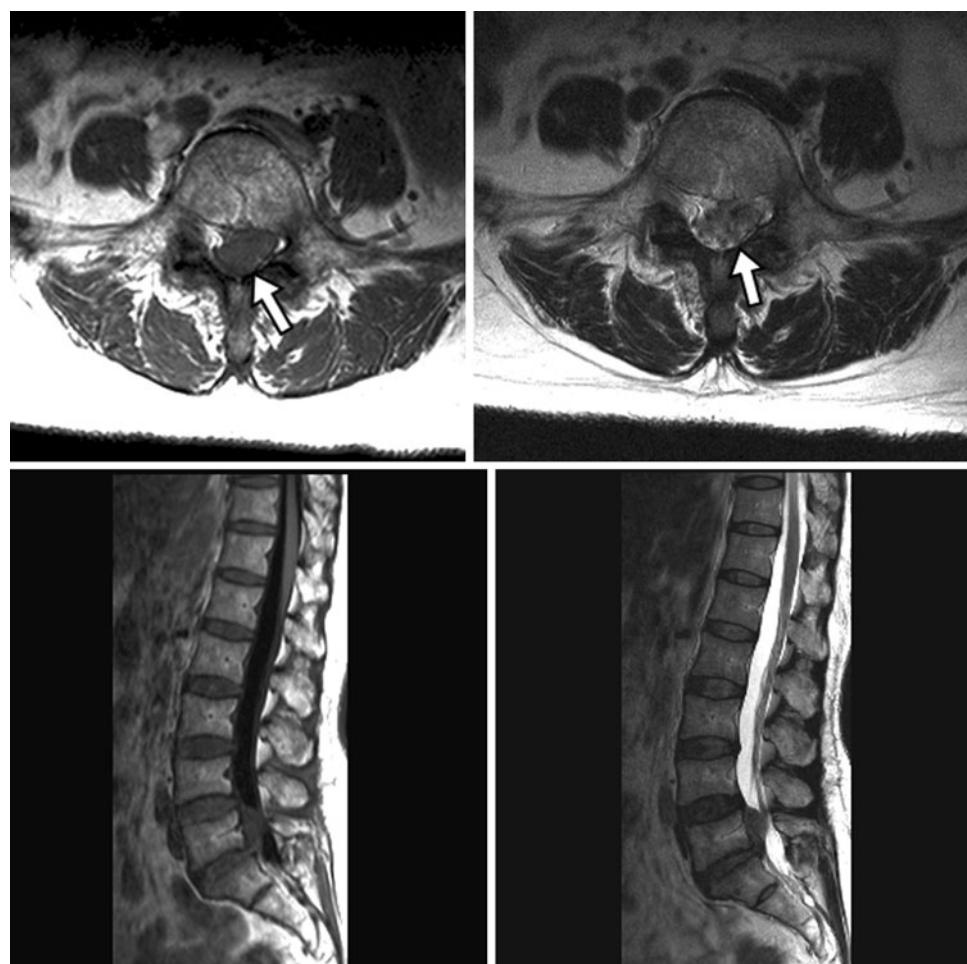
Gadolinium-enhanced MRI, T1-weighted image showing ring enhancement (arrow) of the mass; T2-weighted image revealing no peripheral or homogeneous enhancement of the mass
